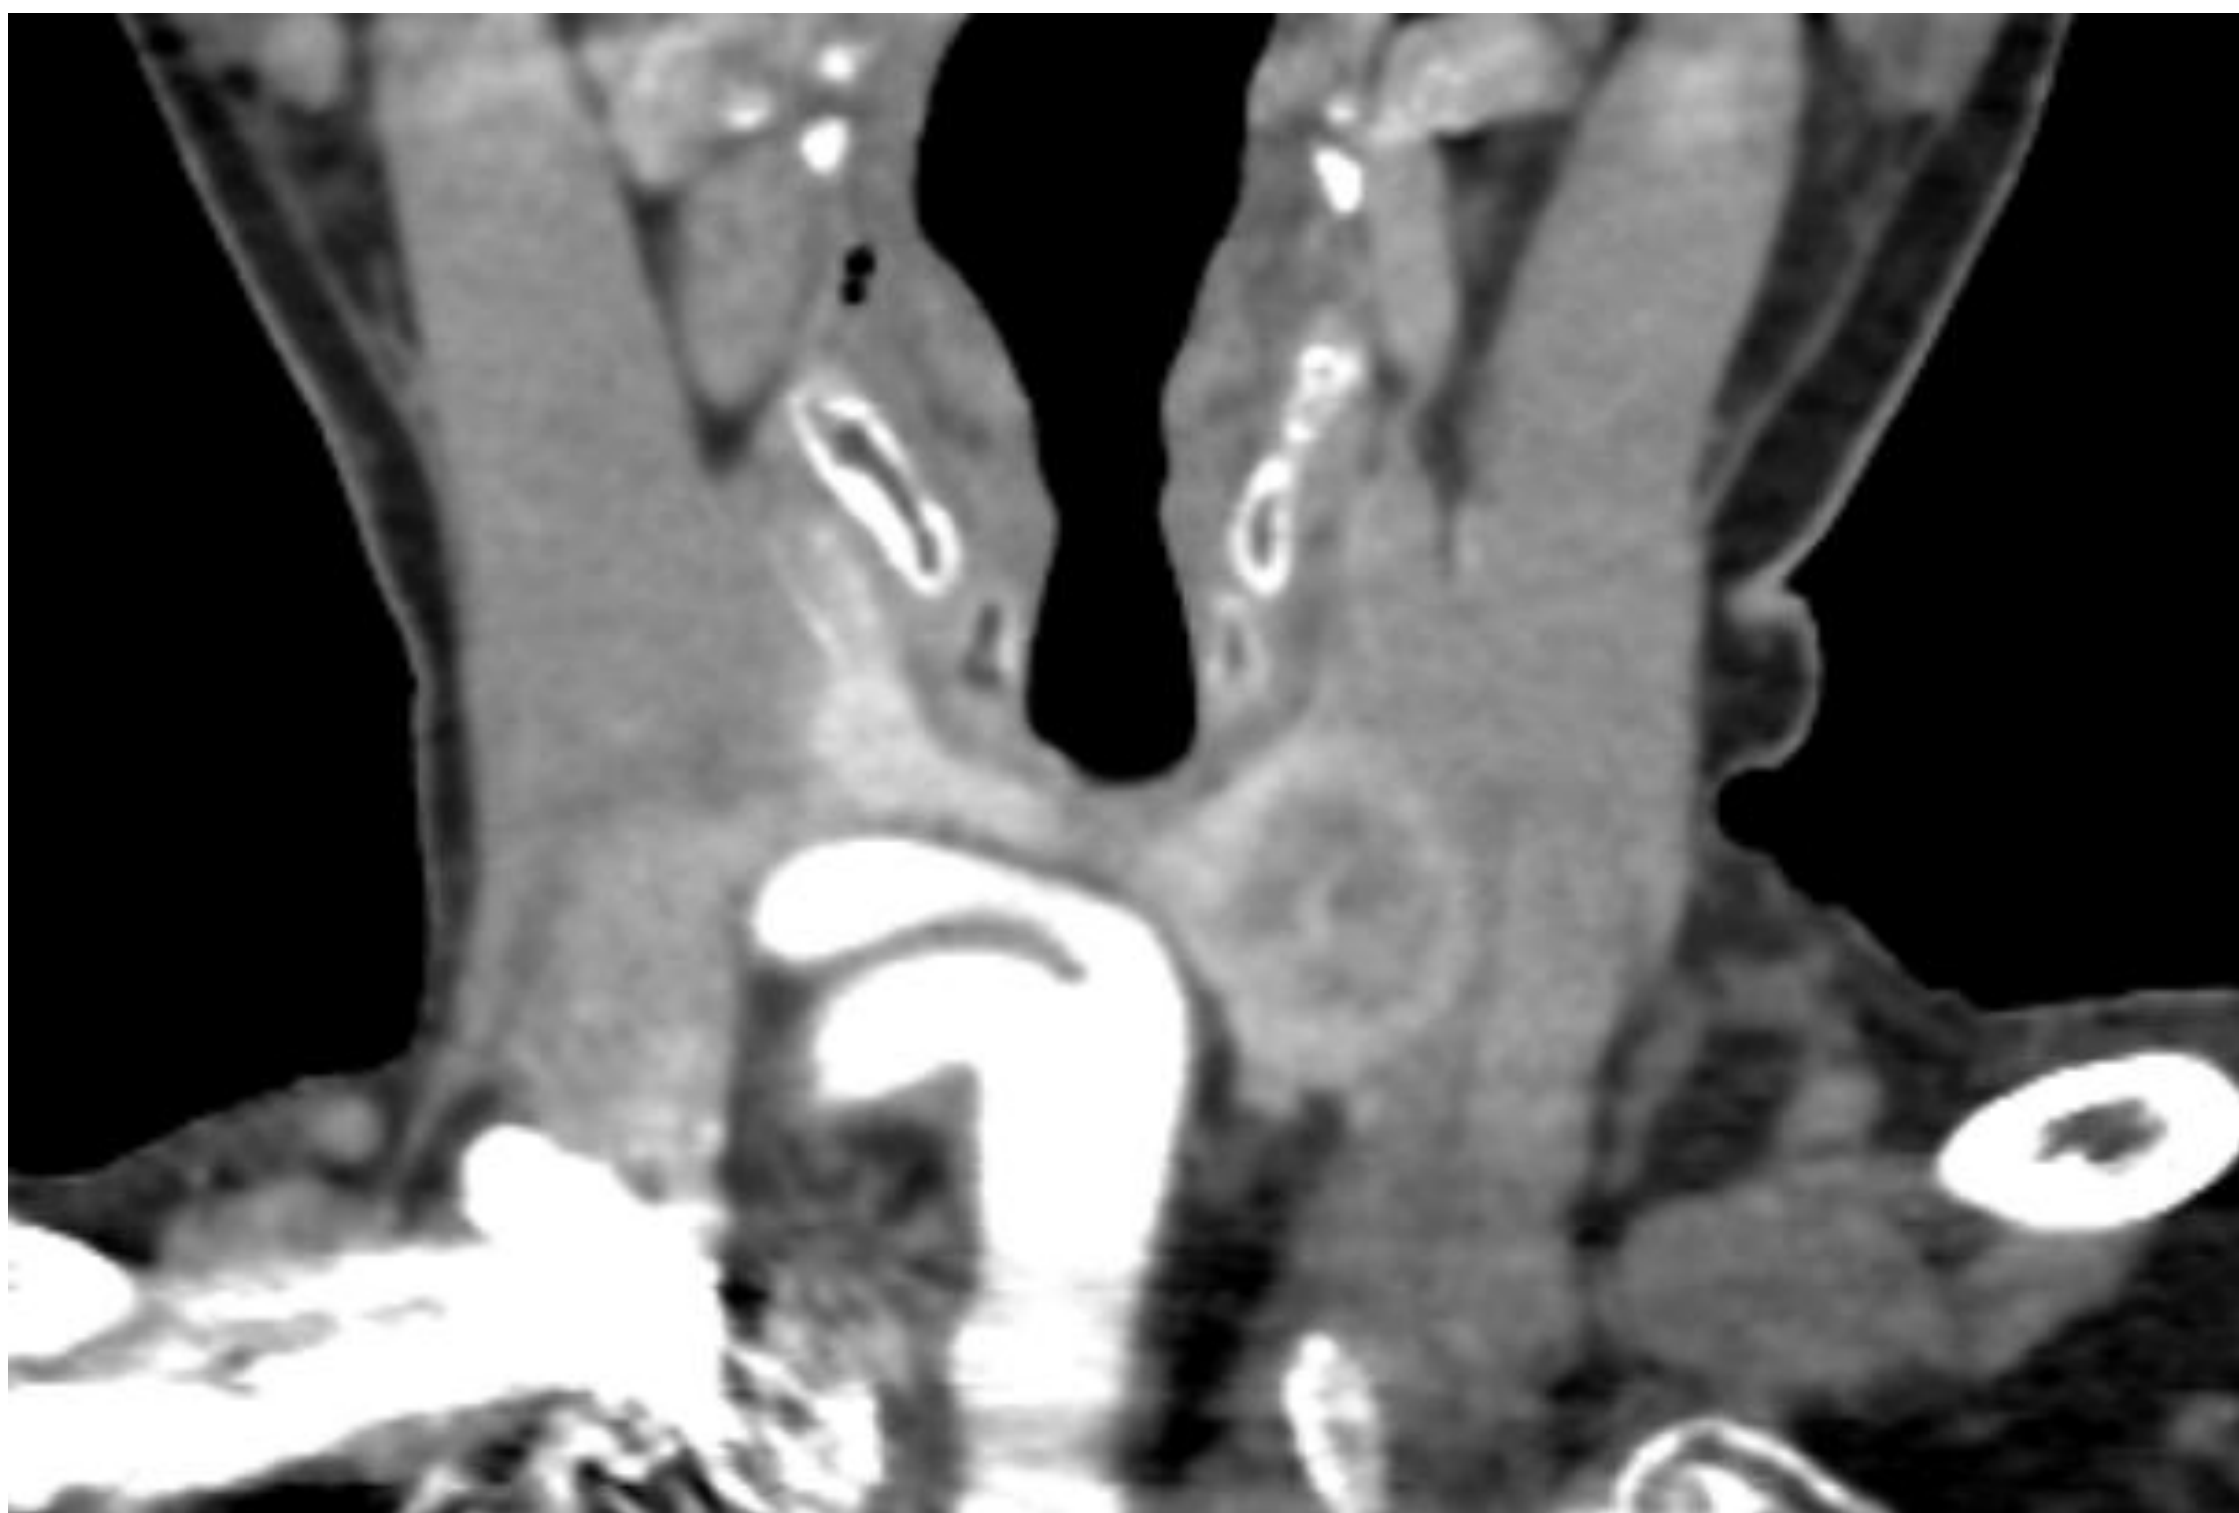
Coronal CT with contrast demonstrating extension of innominate artery to the first tracheal ring.
